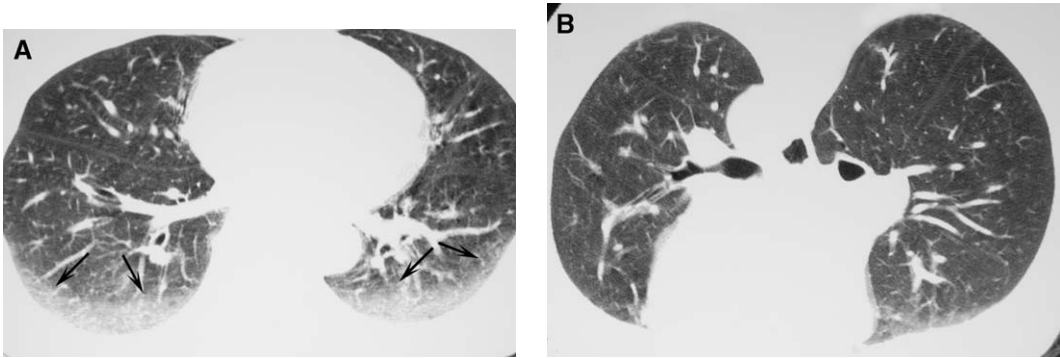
Value of prone HRCT imaging. (A) Axial supine HRCT images shows opacity in the posterior lungs (*arrows*), which could represent either dependent density (atelectasis) or pulmonary inflammation. (B) Axial prone HRCT image shows complete resolution of the posterior opacity, indicating that it represented atelectasis.
